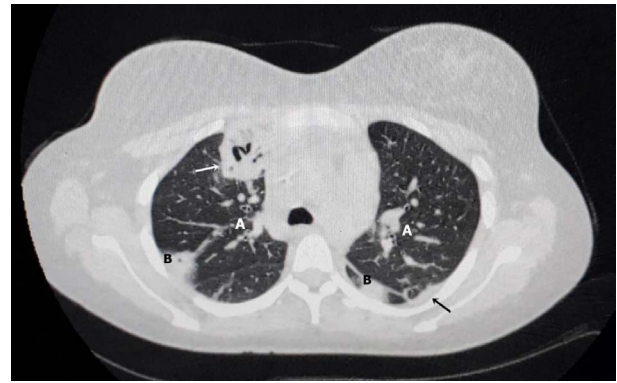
Chest CT: A) Diffuse metastatic nodes in pulmonary window; B) pleural nodes, tuberculous cavity (white arrow) and pleural effusion (black arrow)
